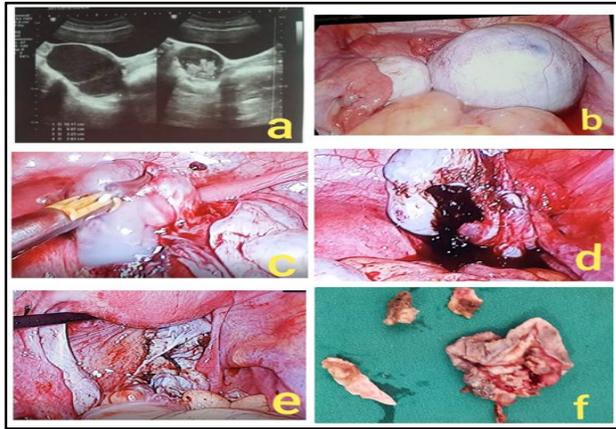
a) Ultrasonography showing complex right ovarian cyst of 12x 10x 9 cm with multiple loculi? endometrial cyst? dermoid cyst, b) Laparoscopic view right ovarian cyst, left ovary normal, c) Mucoïd secretion coming out of some loculi of ovarian cyst, d) Chocolatey tarry secretion coming out of other loculi of cyst, e) Final view after aspirating and enucleating the cyst, f) The enucleated cyst walls sent for HPE.
